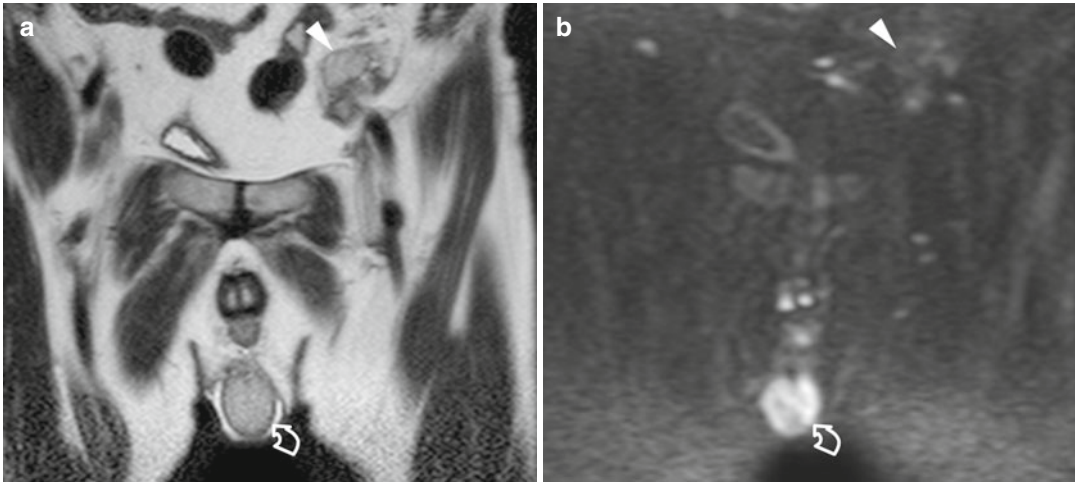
An undescended testis located in the abdomen near the left iliac vessels. (a) Coronal T2-weighted image showing a normally descended right testis (*curved arrow*) and a small left testis adjacent to the left iliac vessels (*arrowhead*). (b) Coronal diffusion-weighted image
